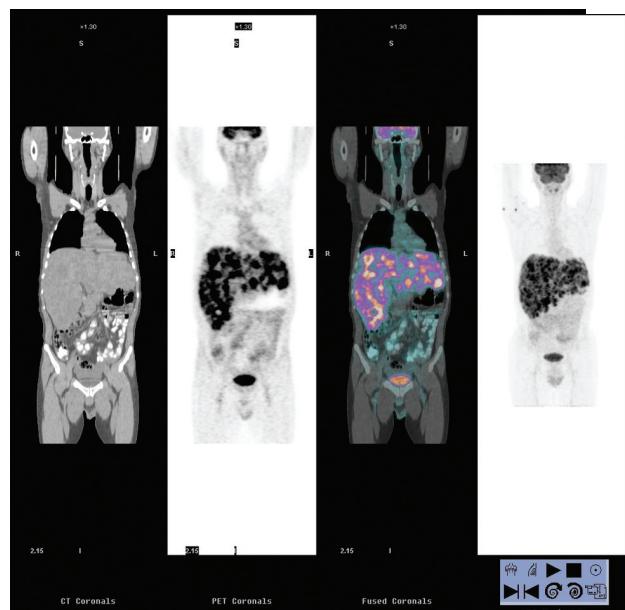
F-18 FDG PET/CT before the therapy. Hepatomegaly and multiple focal hypermetabolic uptake were observed.
